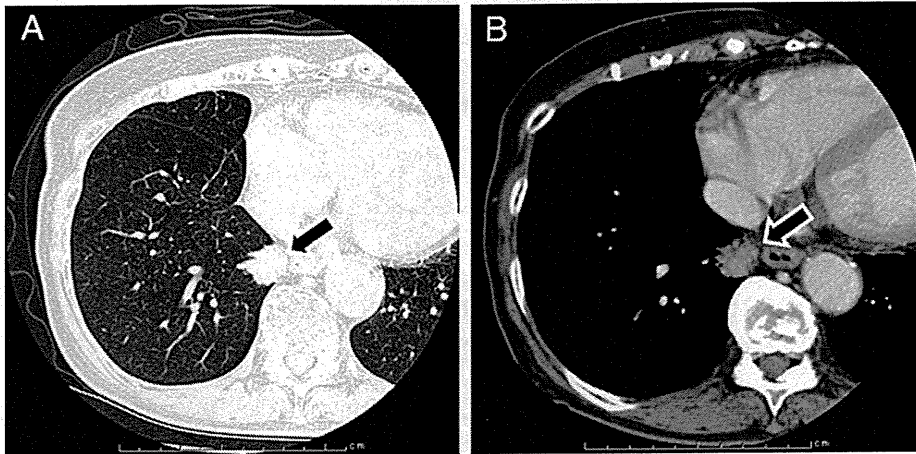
CT demonstrated a round and well-defined nodule with spiculation measuring 21 mm in diameter in the right lower lobe (arrow). (A) The density of the lung. (B) The density of the mediastinum.
